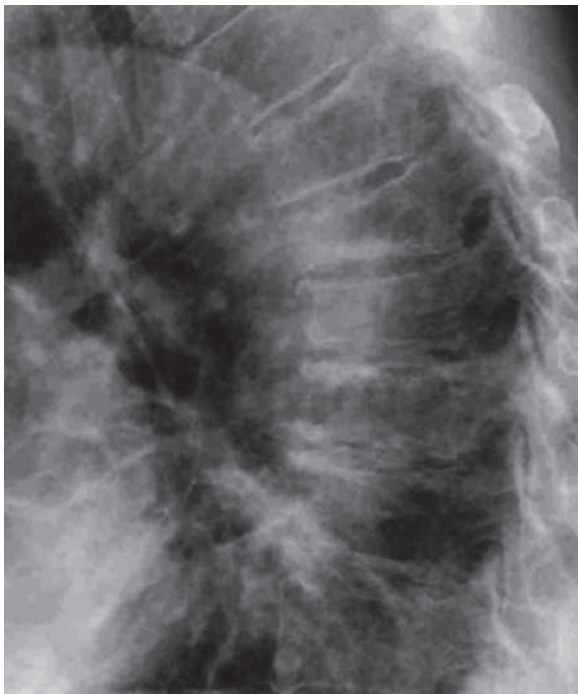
A lateral thoracic vertebrae radiograph shows kyphosis of the thoracic vertebrae due to osteoporosis (Dowager's Hump)
